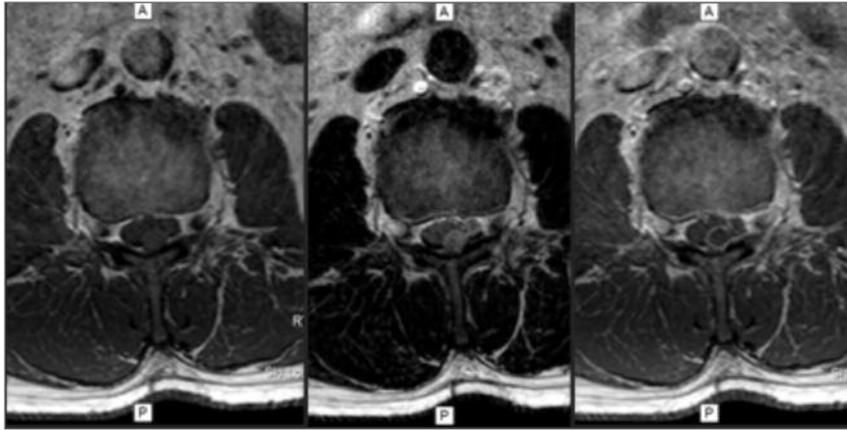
Axial MR images of the lumbar spine (L2-L3) showing a right posterior epidural lesion (from left to right: T1-weighted image, T2-weighted image and T1-weighted image after gadolinium injection).
